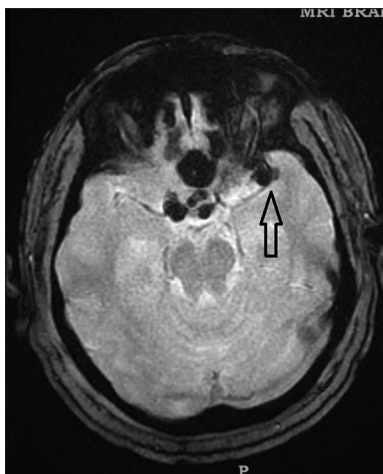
Magnetic resonance imaging of the brain showing multiple hypoechoic area indicating the air pockets in the subarachnoid space. Arrow indicating air pocket compressing the middle cerebral artery branches in the left sylvian fissure
